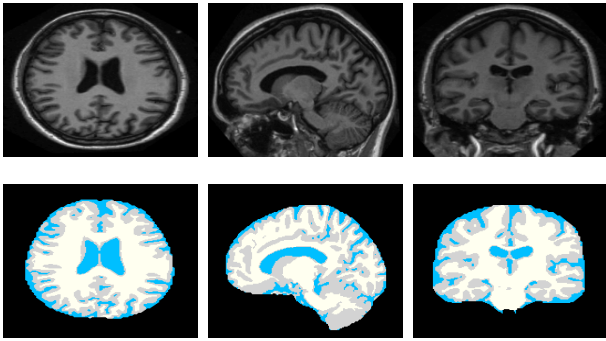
Sample subject of the OASIS dataset publicly available in <http://www.oasis-brains.org>. Top row: Motion corrected MR image. Bottom row: Provided structure segmentation. Left to right: Axial, Sagittal and Coronal axes.
